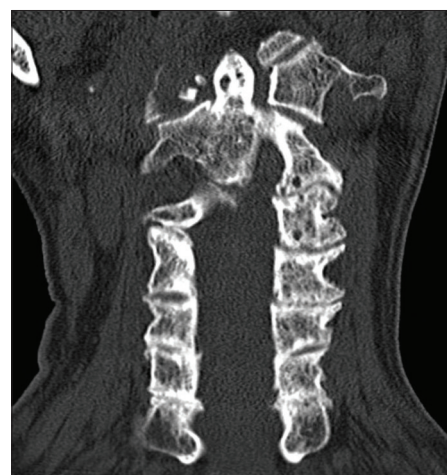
Preoperative coronal computed tomography scan demonstrating the C1 fracture pattern of the lateral mass.
